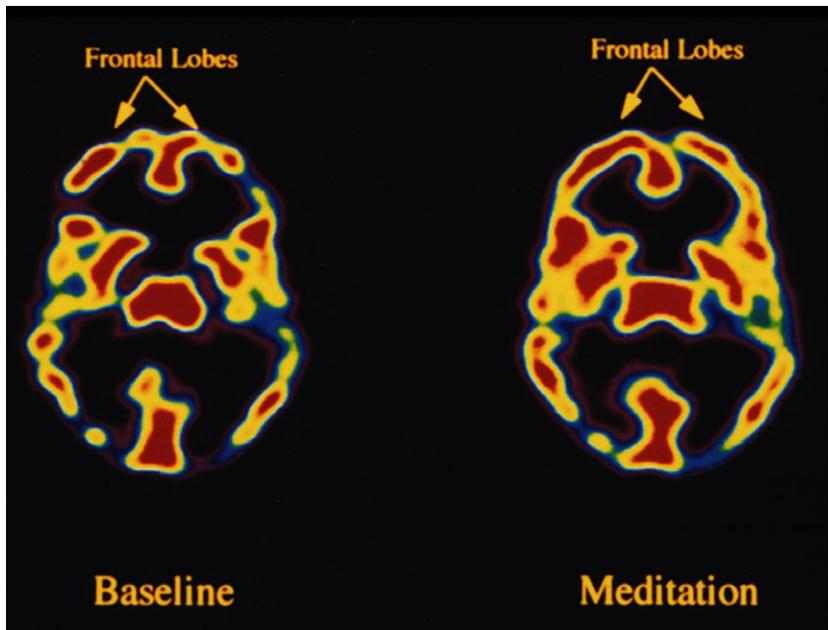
SPECT scans of a subject at rest and during peak meditation showing increased cerebral blood flow (arrows) during meditation.
